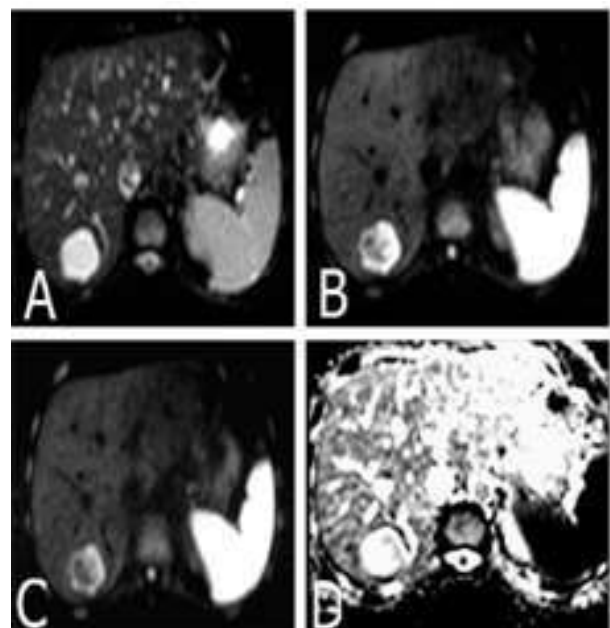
Showed diffusion weighted MRI of 45 years old male patient with haemangioma, DWI, at b0(A), DWI at b500(B), DWI at b1000(C) and ADC map(D) shows mixed high SI with high mean ADC value at b1000 = $2.10 \text{ A}3 \text{ mm}^2/\text{s}$.
